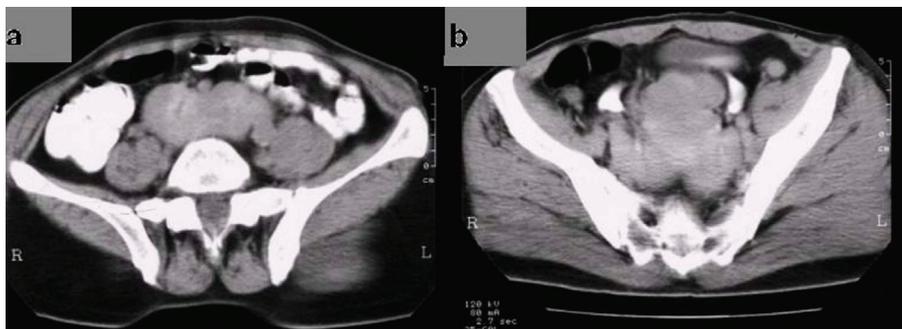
(a, b): Oral and IV contrast enhanced axial CT shows that the kidneys are not located in their normal positions (a). In the pelvic region a single mass of kidney with lobulated contours and two ureters are detected (b).
